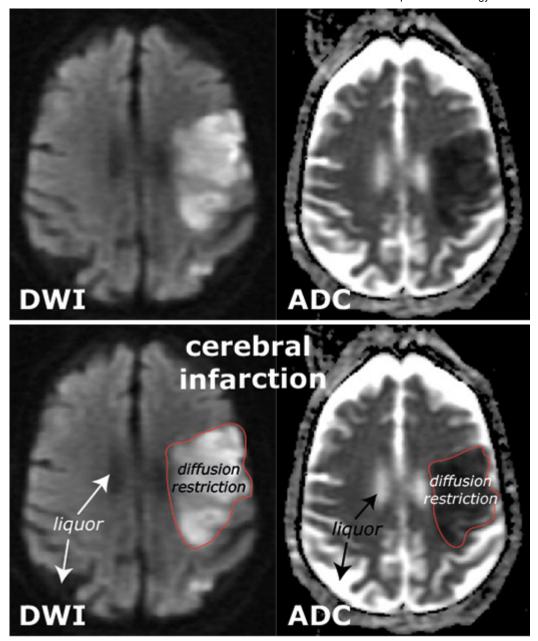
Diffusion restriction secondary to cytotoxic edema in an infarction in the left hemisphere (middle cerebral artery territory). The DWI has high signal intensity and ADC low signal intensity. Note also the (physiologically) increased diffusion of the CSF.
